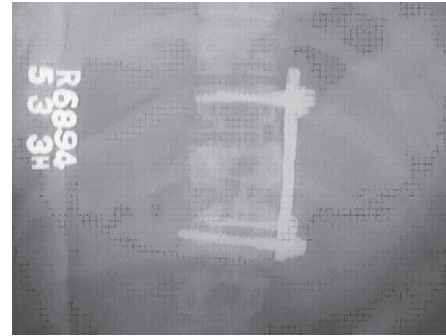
post operative X-Rays showing cage placement and plating (TSRH)
